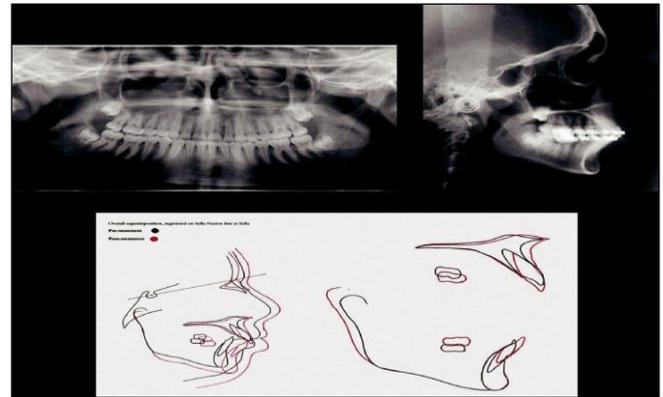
Posttreatment radiographs with superimpositions
